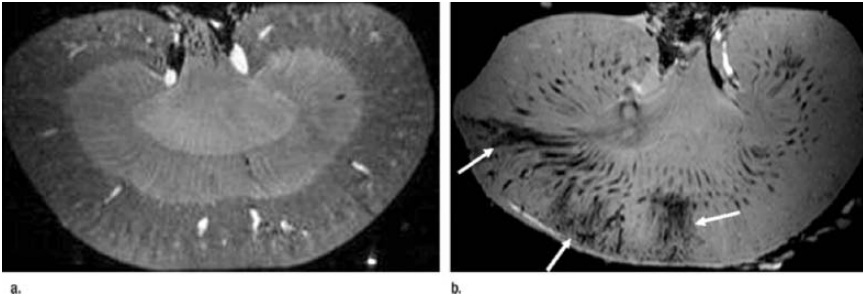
a Ex vivo sagittal three-dimensional T_2^* -weighted (110/15.7, flip angle of 30°) 9.4 T MR images of (a) control and (b) pathologic kidney 6 days after intravenous injection of 10^7 -labeled MSCs (the upper pole is oriented left). In a, no signal intensity decrease is noted. In b, the corticomedullary differentiation is absent and distinct areas of cortical signal intensity decrease are present in the superior and superior midportion. b Ex vivo sagittal three-dimensional T_2^* -weighted (110/15.7, flip angle of 30°) 9.4 T MR images of (a) control and (b) pathologic kidney 6 days after intravenous injection of 10^7 -labeled MSCs (the upper pole is oriented left). In a, no signal intensity decrease is noted. In b, the corticomedullary differentiation is absent and distinct areas of cortical signal intensity decrease are present in the superior and superior midportion (arrows) poles. Reprinted from Hauger et al. (2006). Reproduced with permission from the Radiological Society of North America.
